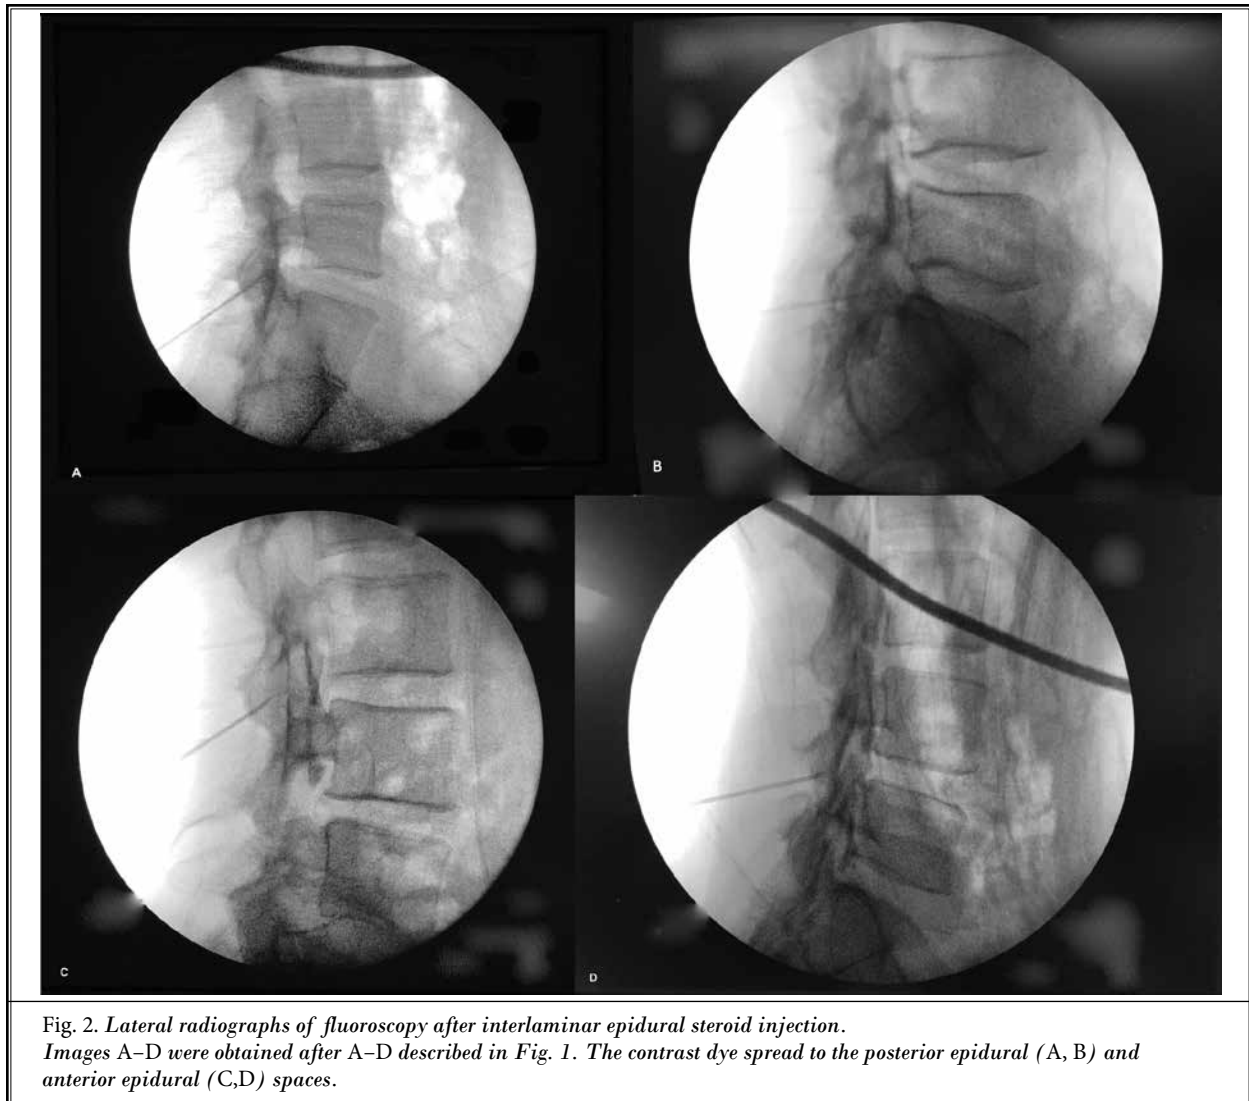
Lateral radiographs of fluoroscopy after interlaminar epidural steroid injection. Images A–D were obtained after A–D described in Fig. 1. The contrast dye spread to the posterior epidural (A, B) and anterior epidural (C,D) spaces.
